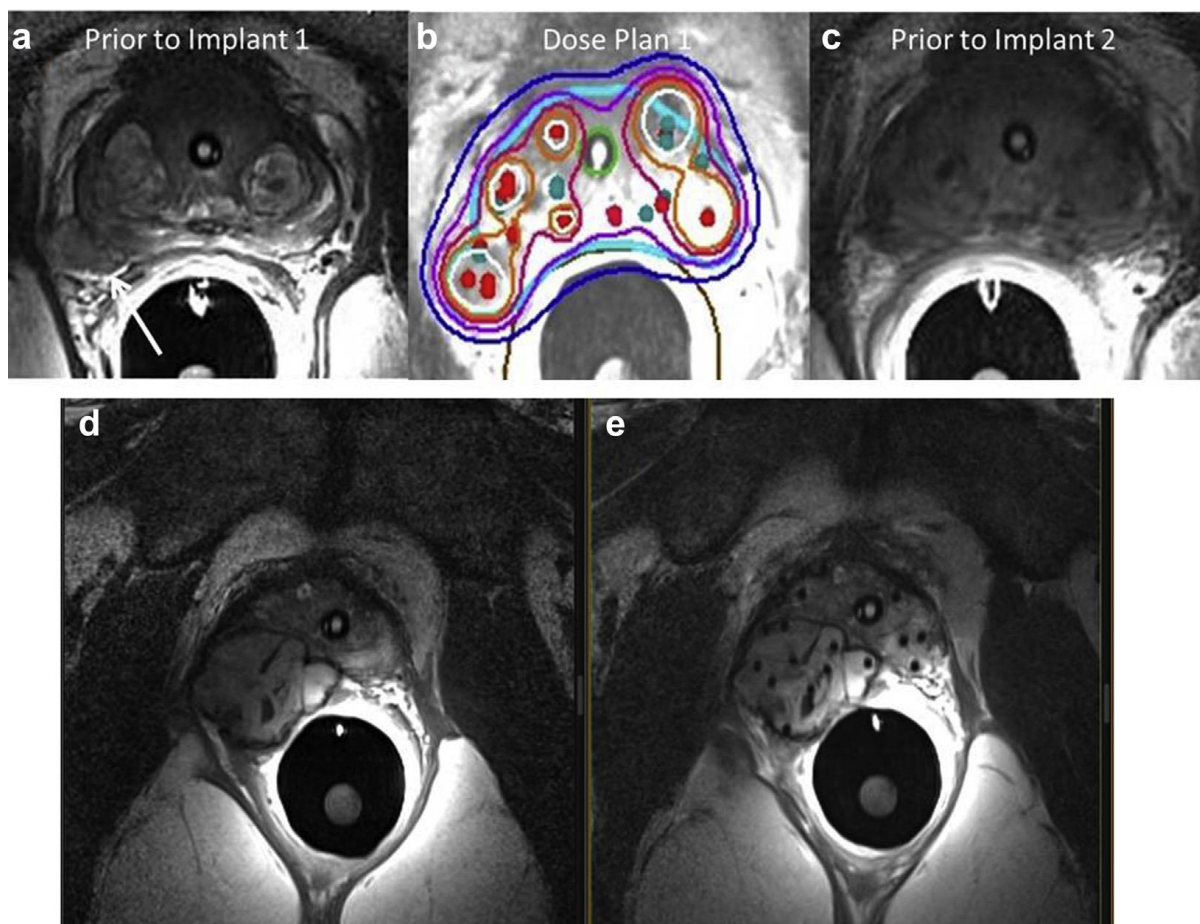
Example of extracapsular extension (MRI T3a). Patient initially presented with high-risk prostate cancer with known T3a disease before the brachytherapy. Left panel (a): T2-w MRI before first implant showing gross extracapsular extension (arrow). Middle (b): implant with isodose plan (blue line=75% isodose, pink line=100% isodose). Note complete coverage of extraprostatic disease with 100% isodose). Right (c): MRI before the second implant. Note significant reduction in extraprostatic disease in response to treatment. This enabled reduced rectal dose exposure. Second row (d): Example of large locally advanced prostate cancer. (e): MRI guidance allowed implantation of the large right-sided extraprostatic tumor abutting the rectum.
